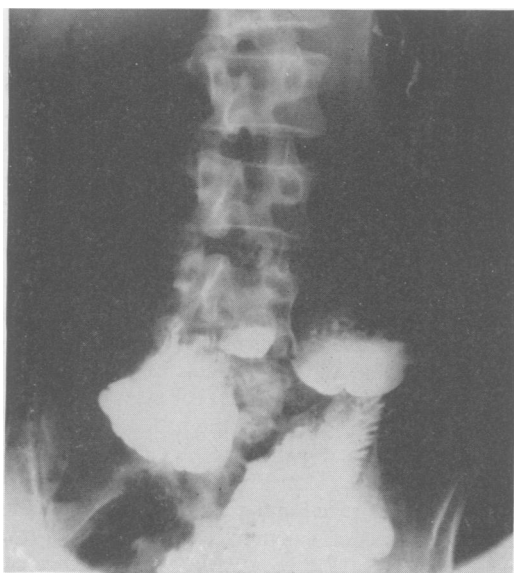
Gastro-intestinal x-ray on 12th postoperative day 25 minutes after barium ingestion. Duodenum still dilated.
